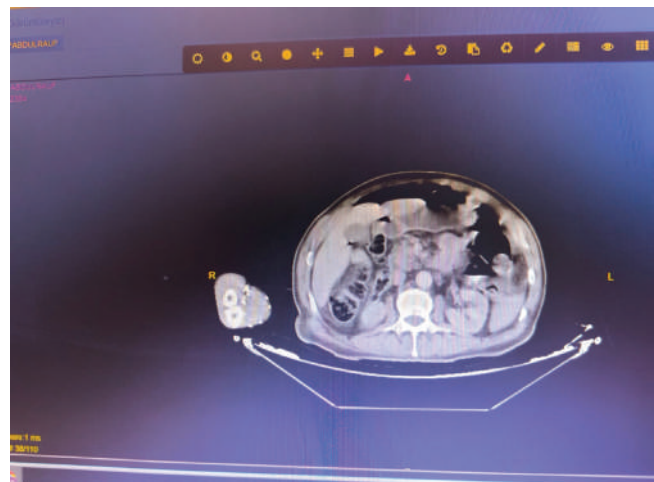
Computed tomography (CT) image. Intra-abdominal free air image in CT scan.
